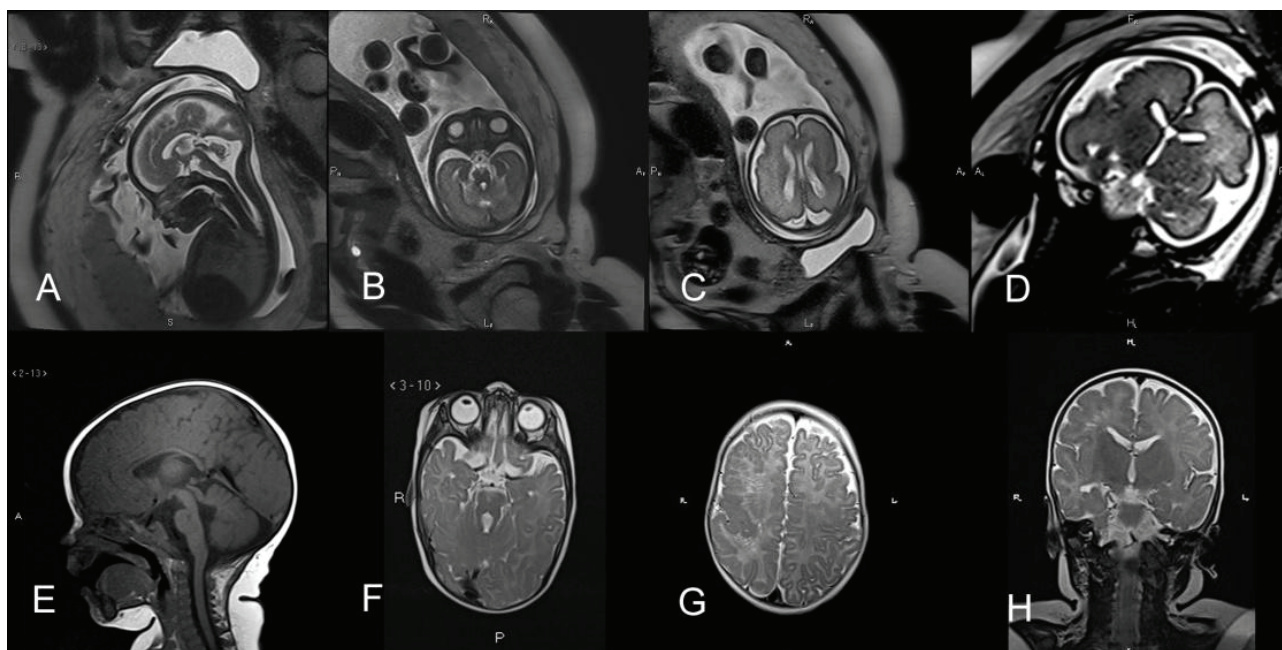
Fetal and postnatal magnetic resonance imaging features of Joubert syndrome and related disorders with unilateral polymicrogyria and white matter microcysts.
